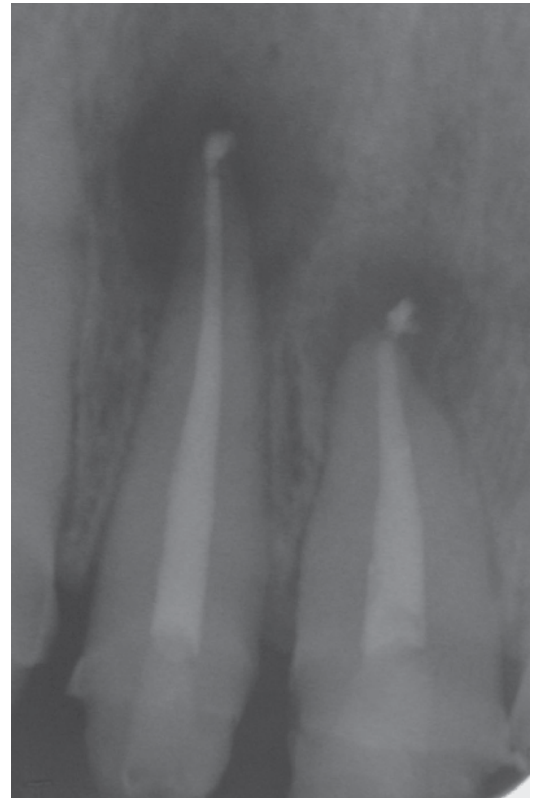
Radiograph of the upper right central incisor and lateral incisor filled with the thermoplastic gutta percha technique.
